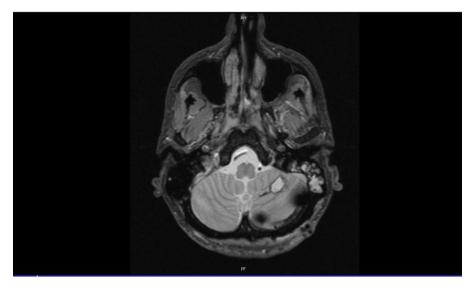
Brain MRI after stereotaxic biopsy.
